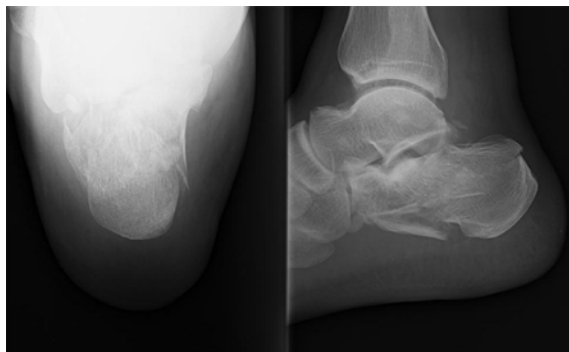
Computed radiographs (CR) of intra-articular calcaneal fracture (left: axial view; right: lateral view).
